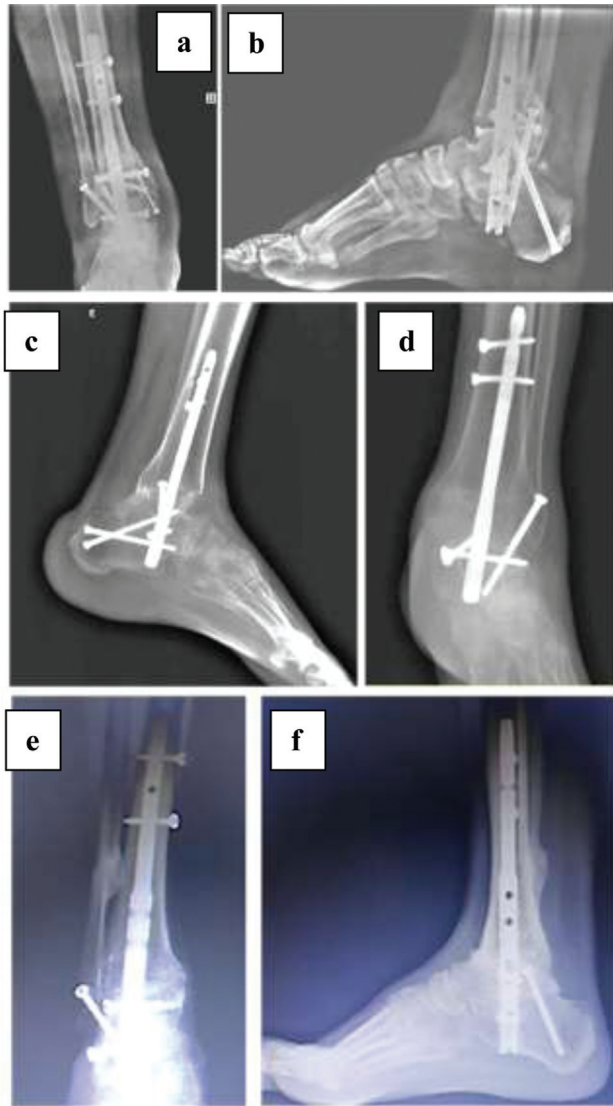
Radiographic aspect in the late postoperative period of cases 1 (a, b), 2 (c, d) and 3 (e, f).
